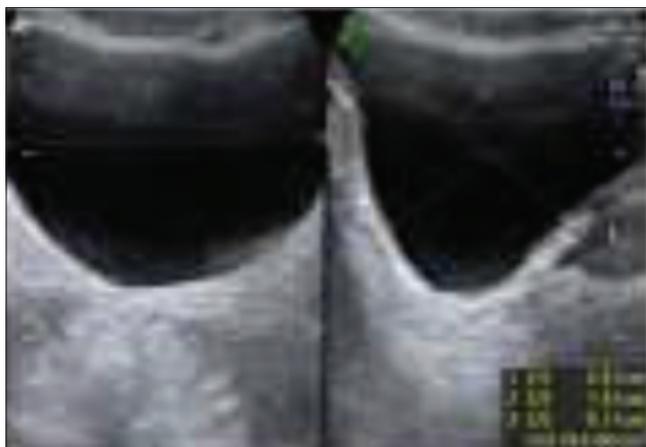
Full bladder volume by transabdominal sonography
